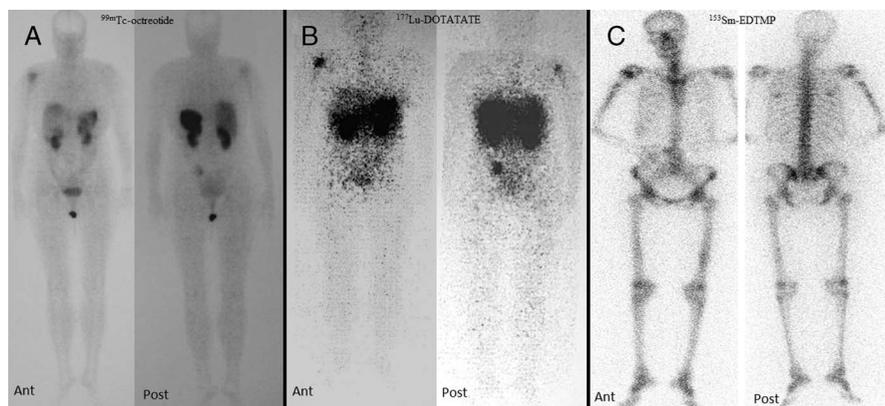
A 45-year-old woman with bone pain utmost right shoulder and previous surgery for breast angiosarcoma. Whole-body scintigraphy using ^{99m}Tc -octreotide scan revealed lesions in the right humerus and left iliac bone regions (A); therefore, she underwent 3 cycles of ^{177}Lu -DOTATATE treatment with 2-month interval (22.2 GBq) (B). She showed a pathologic fracture in the right humerus, so she performed surgery for this fracture and received ^{153}Sm -EDTMP (3.7 GBq) for bone pain palliation (C).
